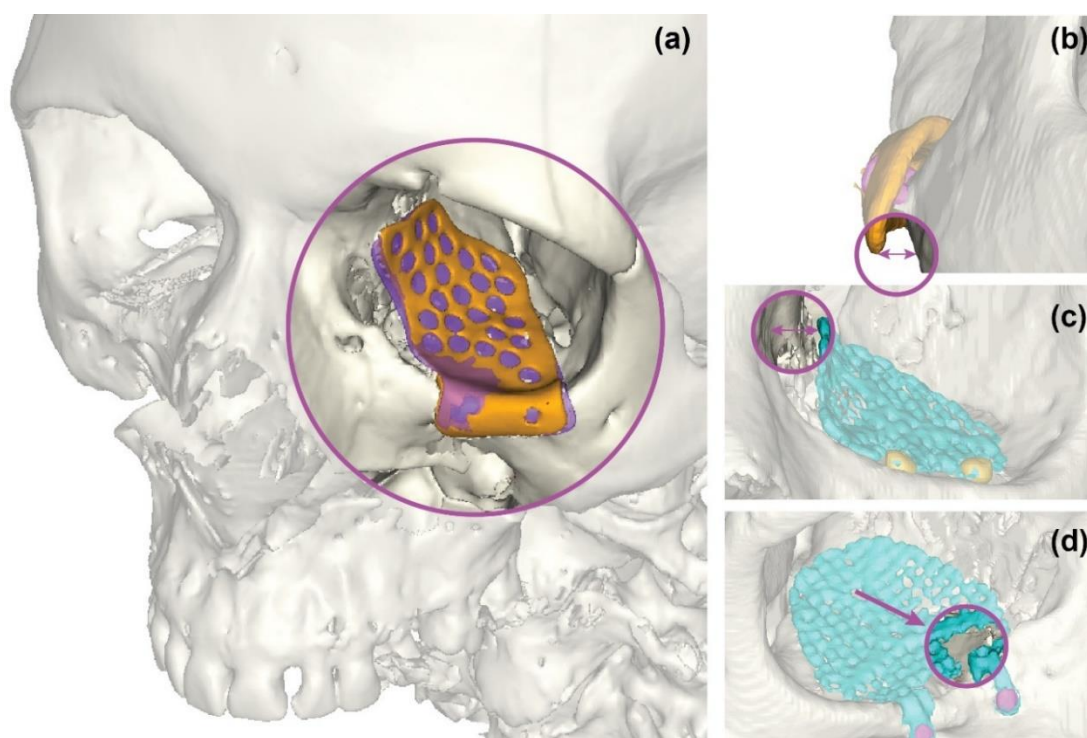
Reconstruction accuracy assessment of fused filament fabrication (FFF) 3D-printed BaSO₄-PEEK orbital implants. (a) Overlay of planned (orange wireframe) and actual (purple solid) FFF BaSO₄-PEEK implant position with magnified inset. Representative postoperative computed tomography (CT) findings: (b) FFF BaSO₄-PEEK implant with gap at infraorbital rim (purple circle), (c) Titanium mesh with gap at medial orbital wall (purple circle), and (d) Titanium mesh with metal artefacts (arrow, purple circle) limiting visualisation of implant position.
